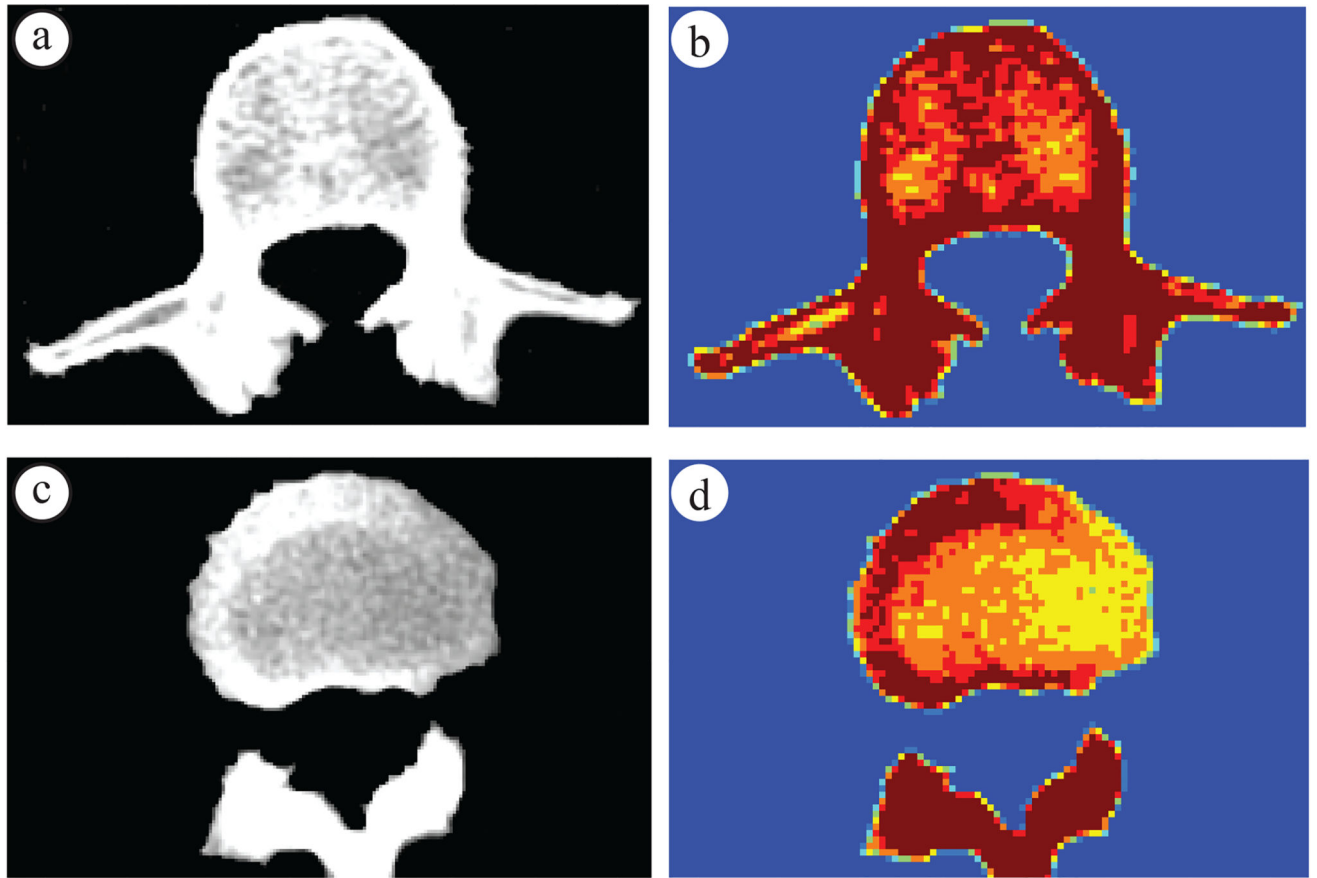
(a) First and (c) fourth images among the stack of four CT images of human vertebra and corresponding quantized images (b, d), respectively, at $I=8$.
